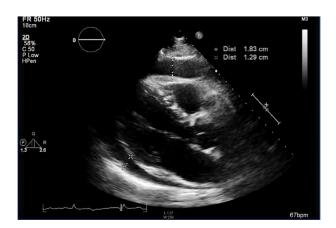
Echocardiography demonstrating fluid in the pericardial cavity with non-collapsing right ventricle during cardiac cycle.
